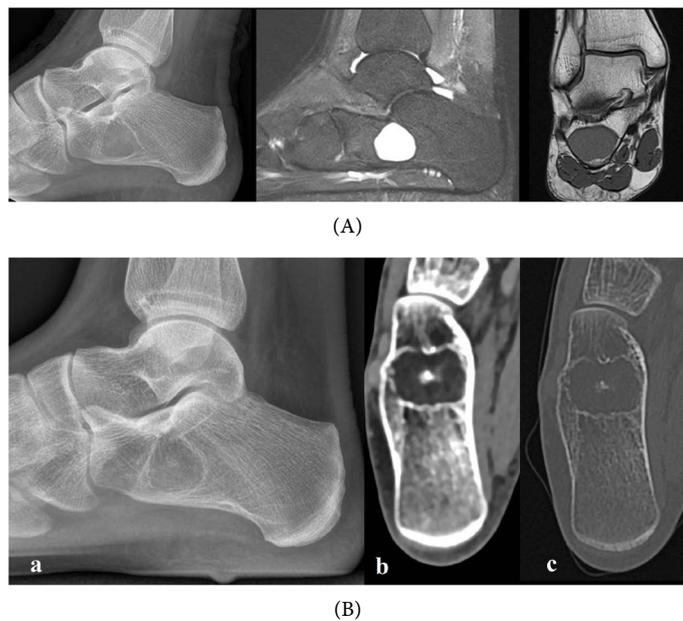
(A) X-Rays and corresponding MRI of calcaneal Unicameral Bone Cyst (April 2018); (B) X-Ray (a) and corresponding CT ((b), soft tissue window; (c), bone window) 2 years after filling with Grafton® DBF Putty/BM (June 2020)-intervention shown in Figure 1. Marginal incorporation probably related to non-force-transmitting region.
